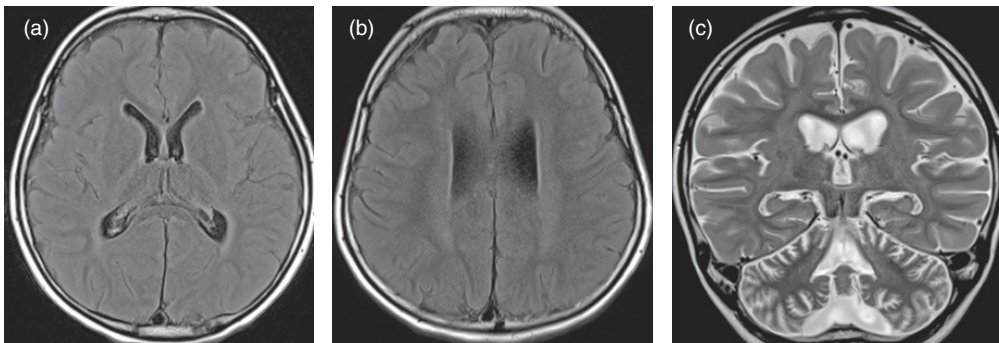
Neuronal ceroid lipofuscinosis type 6 (Batten disease) presenting as developmental regression, deteriorating gait, dysarthria, and tremor at 4 years of age. (a, b) Axial FLAIR and (c) coronal T2-weighted images demonstrate diffuse central white matter T2 hyperintensity, consistent with dysmyelination, accompanied by mild generalized volume loss.
